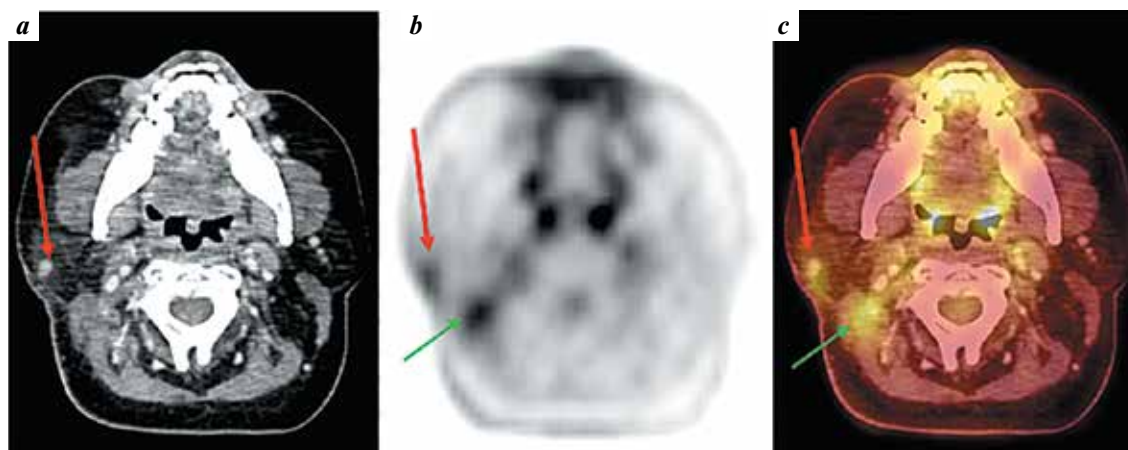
Results of patient examination: a – contrast-enhanced computed tomography (CT) scan; b – ^{18}F -fluorodeoxyglucose positron emission tomography-computed tomography scan; c – ^{18}F -FDG PET-CT scan. Axial view. Nodular formation in the right parotid gland (red arrows); nonspecific radiopharmaceutical accumulation in the upper third of the neck deeply in the postoperative scar (green arrows)
